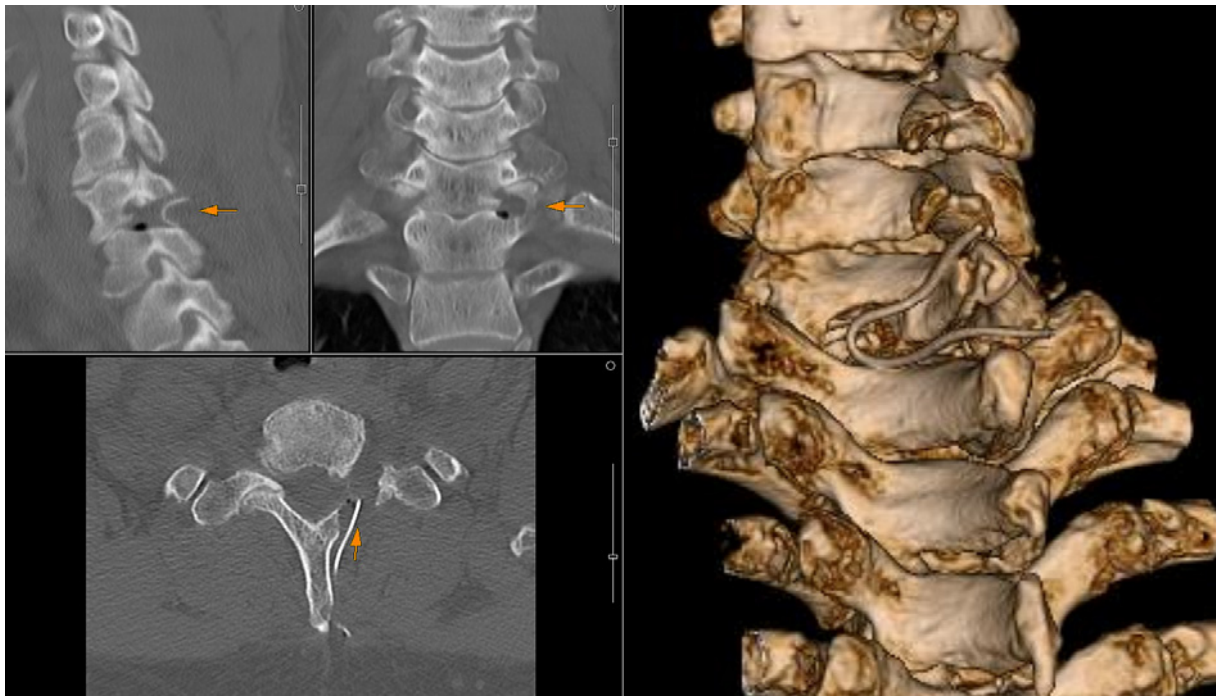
Postoperative CT of case 1.
